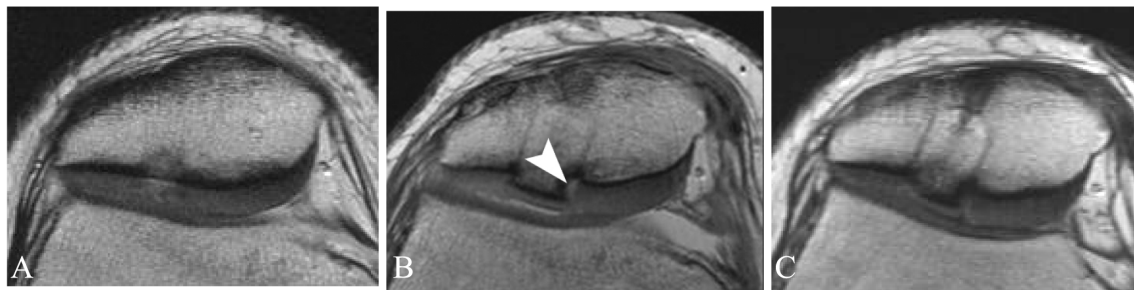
Axial cartilage sensitive fast spin-echo magnetic resonance images in an 18-year-old patient with a patellar autologous osteochondral plug. Before surgery (A), a focal full-thickness cartilage defect affecting the central lateral patellar facet was demonstrated. Four months after surgery (B), the repair cartilage was flush with adjacent native cartilage and isointense signal, despite the offset of the underlying subchondral plate and tidemark. A large fissure was noted at the medial interface (white arrowhead). Sixteen months after surgery (C), the repair cartilage remained isointense. The medial fissure had filled in with presumed reparative fibrocartilage.
